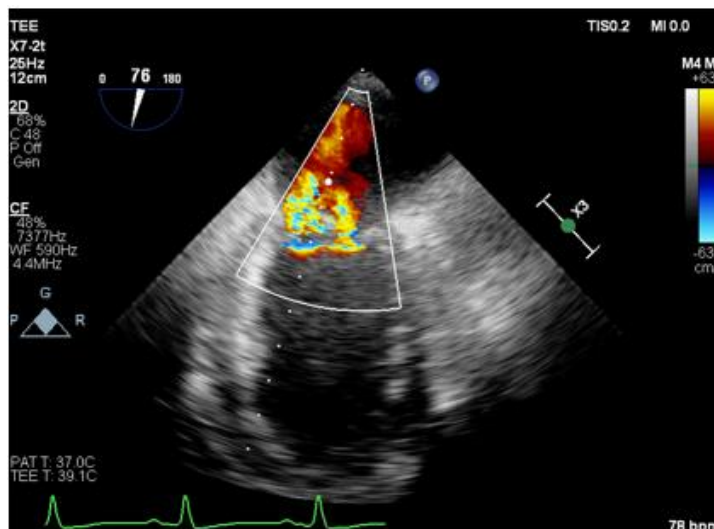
Pre-bypass intraoperative transesophageal echocardiography (TEE). Color Doppler systolic frame showing a dual-component eccentric mitral regurgitation jet: a central jet combined with an eccentric jet tracking posteriorly and inferiorly
